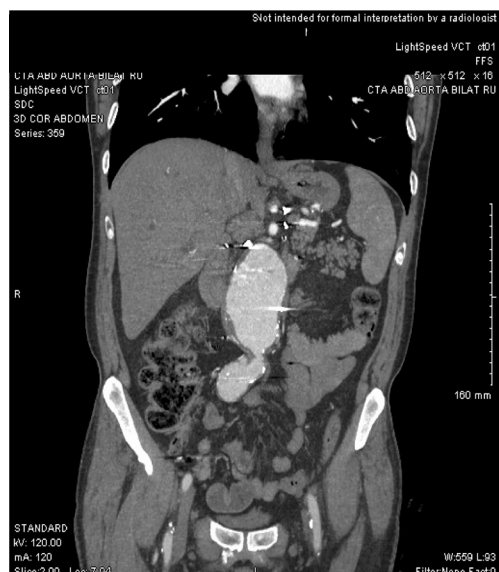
CT angiogram of the abdomen demonstrating the close relation of the abdominal aortic aneurysm with the biliary system.
